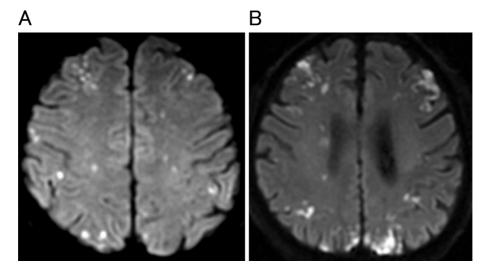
Diffusion-weighted magnetic resonance imaging (MRI) of the brain. (A) Multiple highintensity lesions are identified in the cortical and subcortical regions of the brain (Case 11). (B) Multiple high-intensity lesions are identified in the brain cortex (Case 12).
